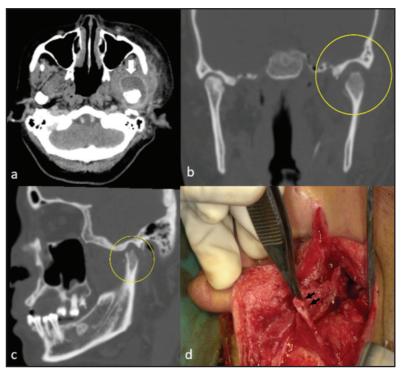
Contrast enhanced CT brain: a. axial soft tissue setting showed rim enhancing collection at the left condylar process (white arrow); b. coronal reconstruction and c. sagittal reconstruction in bone setting showed left condylar erosion, joint widening and subluxation (yellow circle); d. Intraoperatively, left condylar erosion identified (black arrow).
